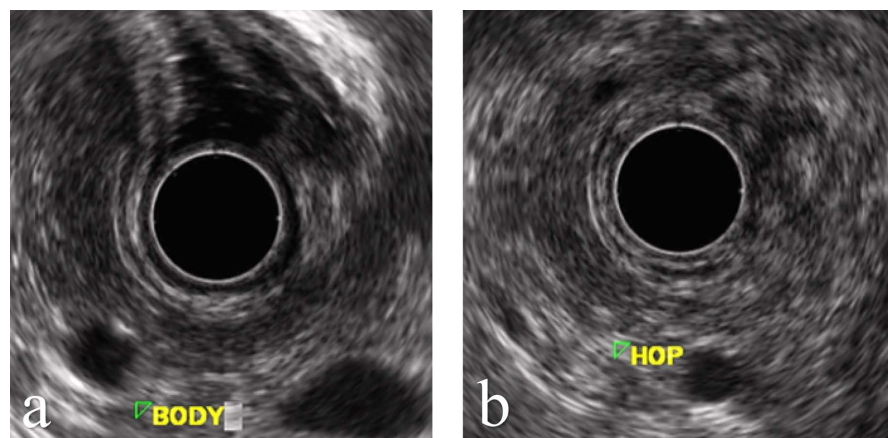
Endoscopic ultrasound of body (a) and head (b) of the pancreas that did not show lesions.
